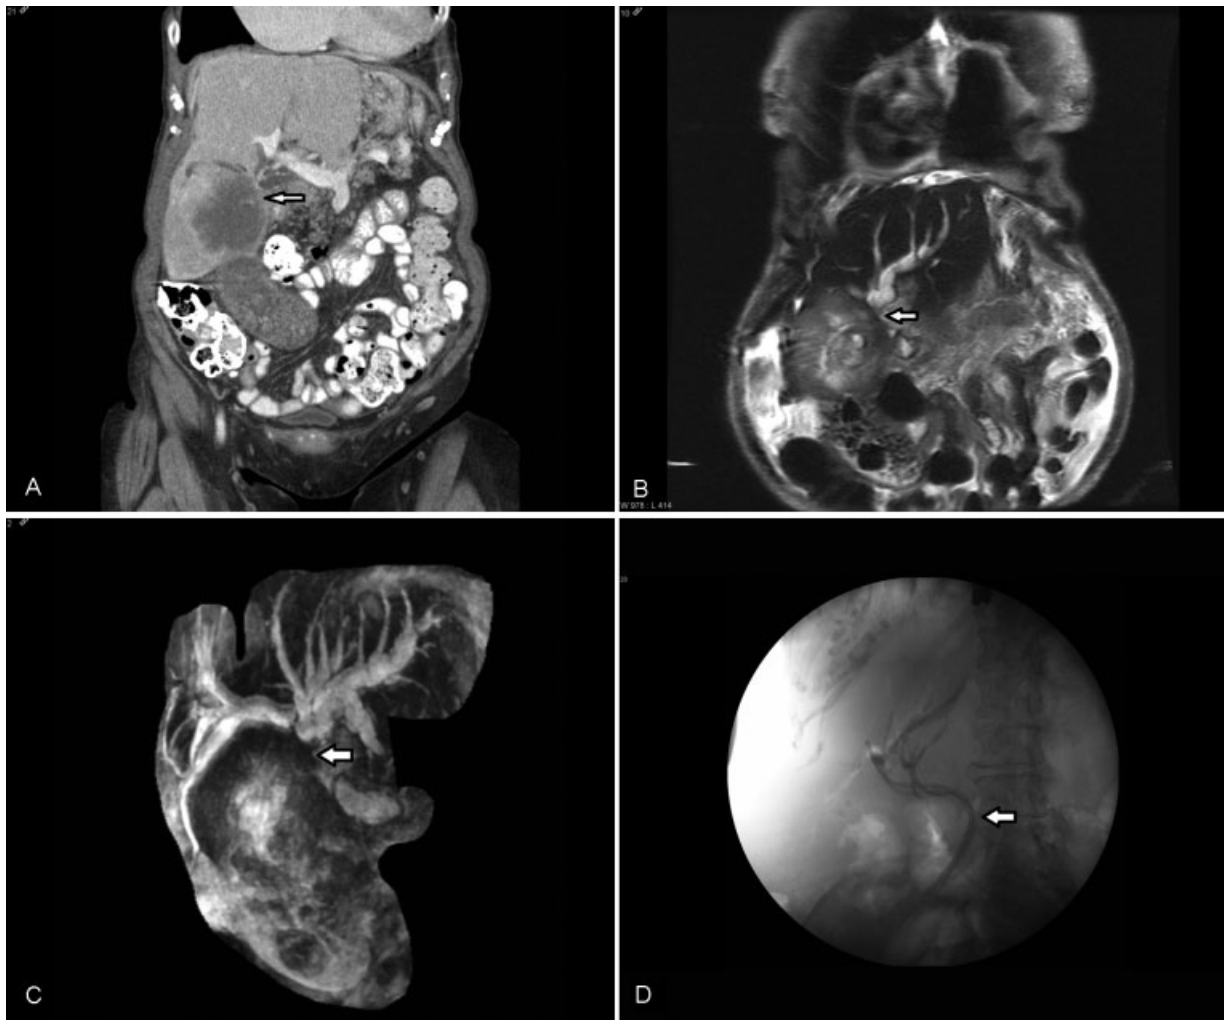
An 82-year-old female patient chronic thrombocytopenia, mechanical mitral valve replacement, atrial fibrillation on warfarin presenting with abdominal pain and elevated liver function tests. (A) Coronal gadolinium-enhanced CT in portal venous phase reveals a large gallbladder adenocarcinoma extending into and involving liver segment 5 with associated common bile duct narrowing and intrahepatic ductal dilatation (arrow). (B) Coronal T2-weighted single shot fast spin echo MR image demonstrates gallbladder mass obstructing the left hepatic bile duct system (arrow). (C) 3D reconstructed MR cholangiopancreatography images revealing common bile duct obstruction due to gallbladder lesion (arrow). (D) Self-expandable metal stents were inserted endoscopically (arrow). 3D, three-dimensional; CT, computed tomography; MR, magnetic resonance.
